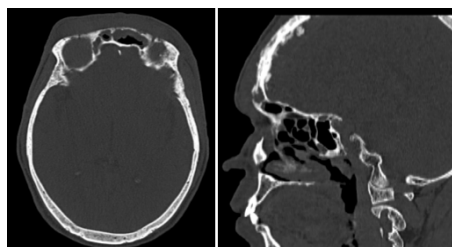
Computed tomography (CT) imaging. A: Axial B: Sagittal bone window shows, ill-defined borders with osteolytic and sclerotic changes of the underlying frontal bone and also of the roof of the orbits.
